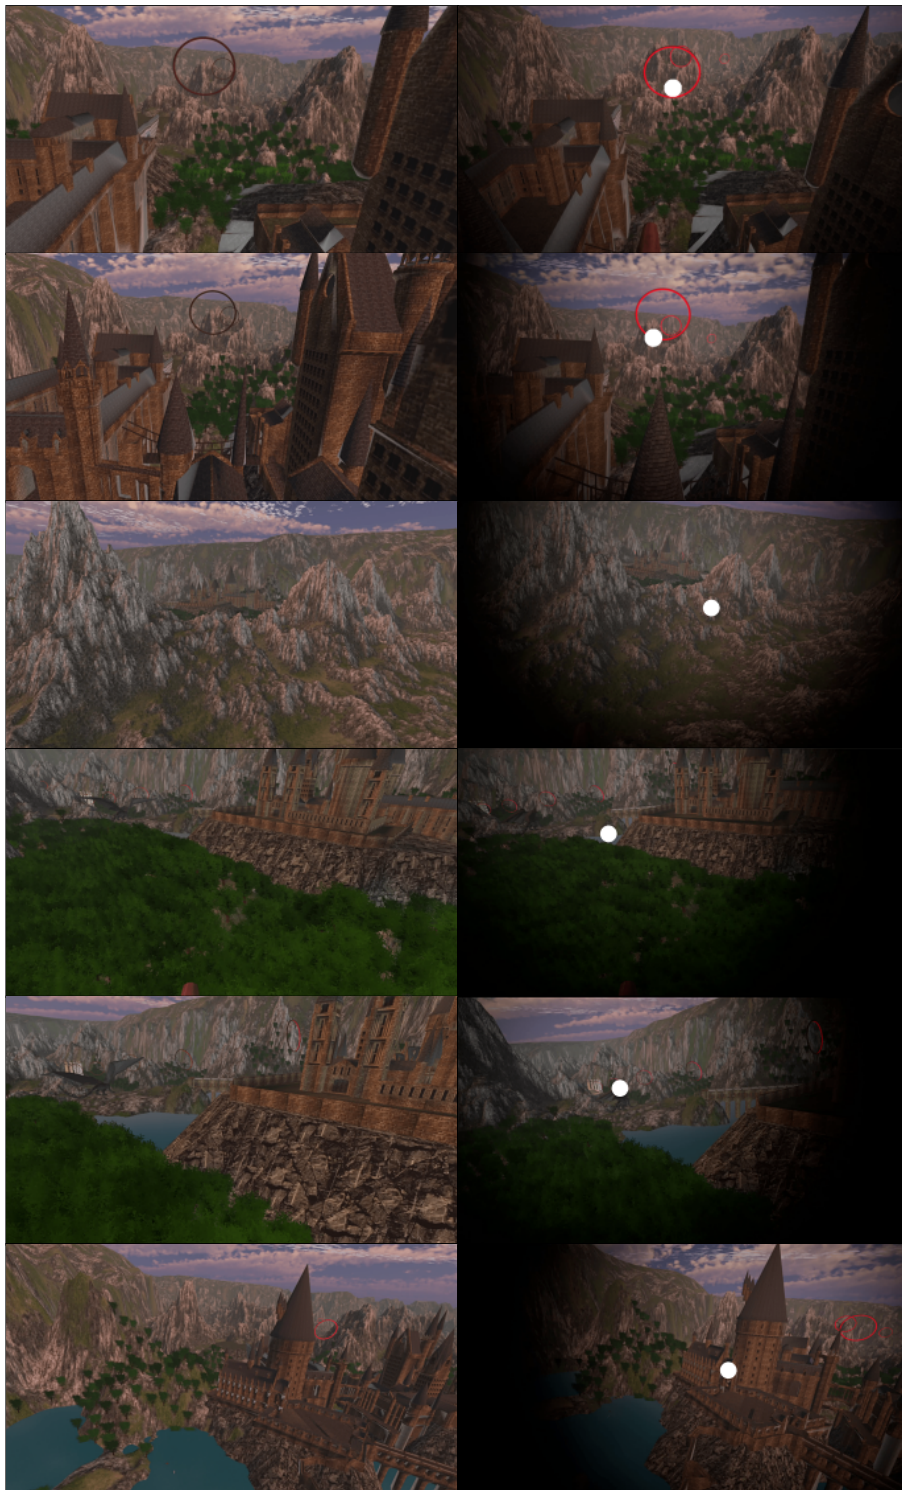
A comparison of frames from the point of view of the user between CT (left) and GV for different speeds and eye-gaze directions (right). White dots have been used to indicate the centre of each vignette on these images.
